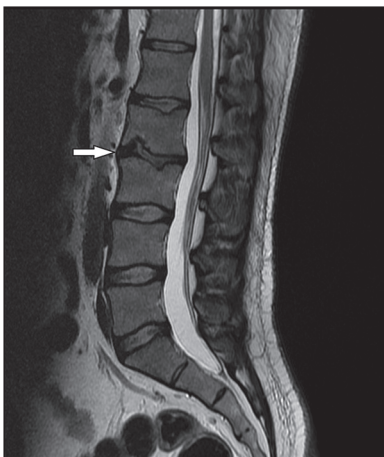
Sagittal T2 weighted MRI image demonstrating degenerated L2-3 disk in patient 1
